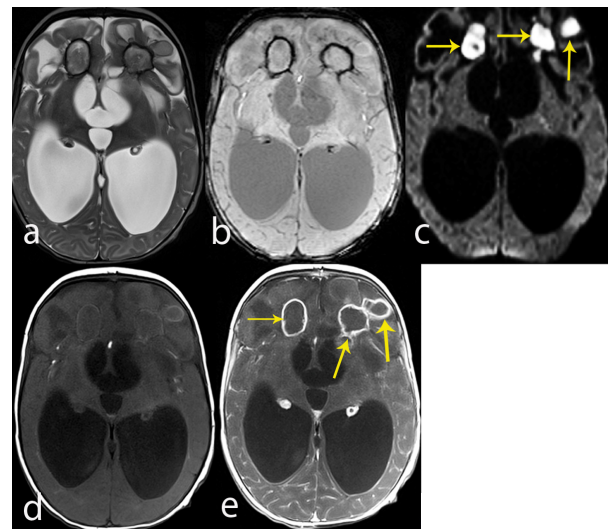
Acute phase of the proteus mirabilis hemorrhagic meningoencephalitis MRI findings. Axial T2W1 (a), SWI (b) and DWI (c) show dark signal intensities suggestive of hemorrhages within the frontal lobes (arrows). Unenhanced axial T1W1 (d) demonstrates hypointense signals in the frontal lobes with sulcal effacement. Contrast-enhanced axial T1W1 (e) shows diffuse leptomeningeal enhancement.
